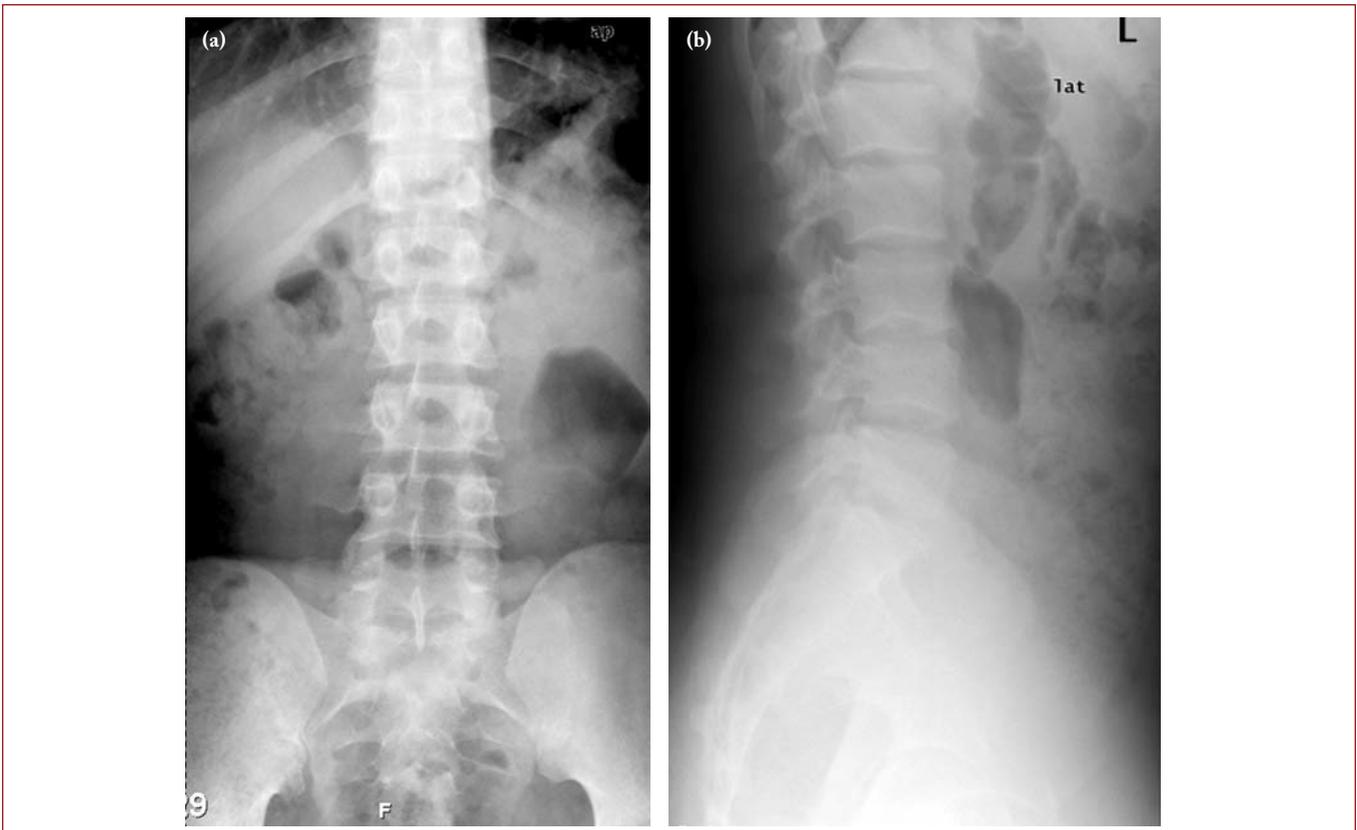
A 25-year-old male patient (S.A.). a. Anteroposterior lumbosacral X-ray showing occult spina bifida and sacralization at the S1 level, b. Lateral lumbosacral X-ray.
